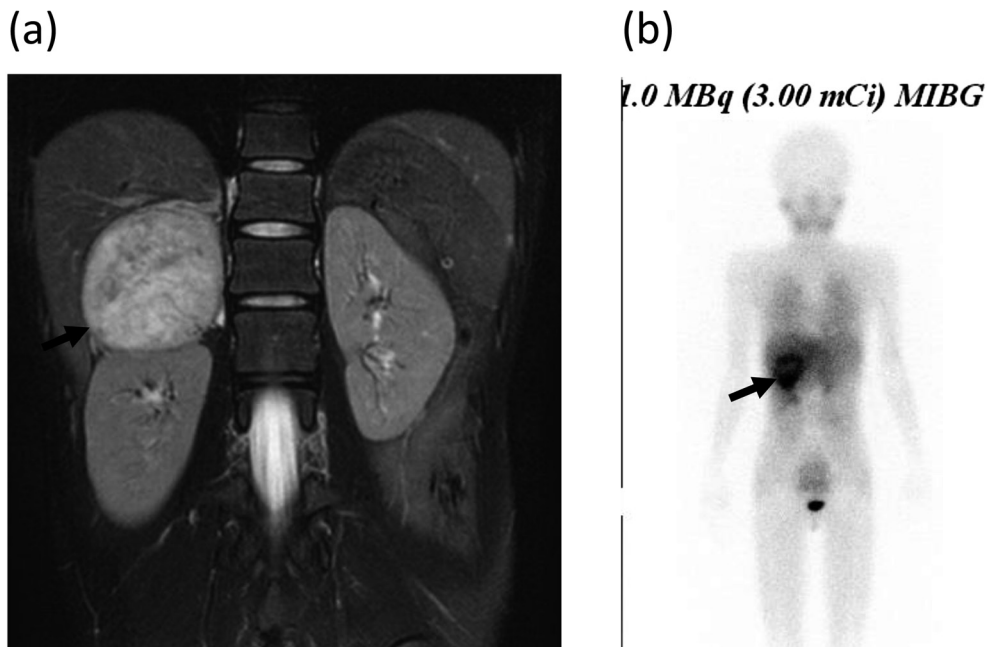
Abdominal magnetic resonance imaging (MRI) and ^{121}I -metaiodobenzylguanidine (MIBG) scintigraphy. (a) Abdominal MRI: T2-weighted MRI showed a well-circumscribed mass with heterogeneous signal intensity (arrow). (b) ^{121}I -MIBG scintigraphy: ^{121}I -MIBG accumulated in the mass (arrow).
